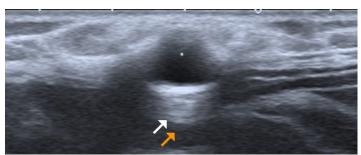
Low Density Hyaluronic Acid (+). Grey scale ultrasound image, transverse view, malar region, shows a round, pseudo cystic nodule not bigger than 2 mm in diameter in superficial location just below dermis
